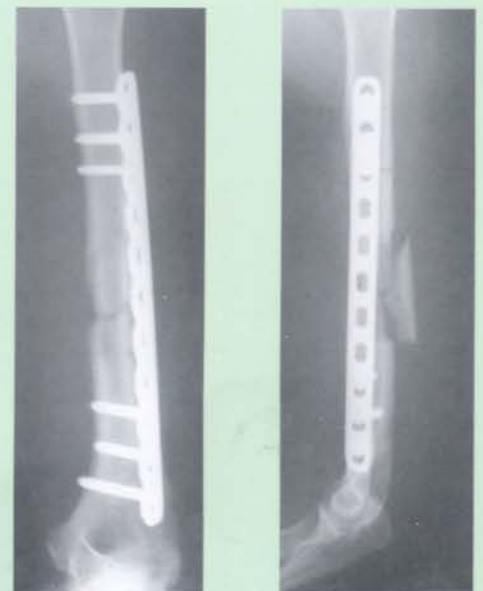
2bc Early postoperative radiographs showing the non-anatomical reduction
